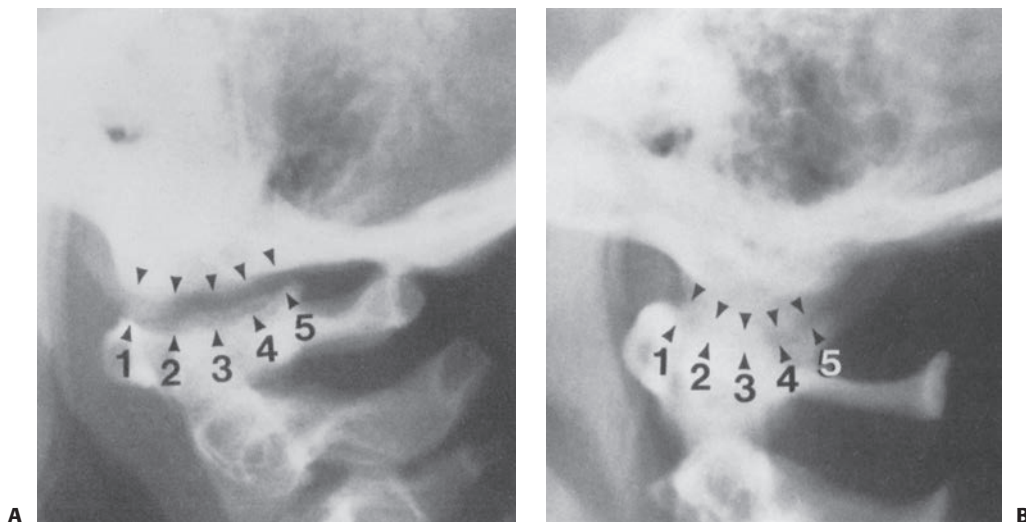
Atlantooccipital joint measurement points 1 through 5 demonstrated on a normal cross-table lateral skull radiograph in an 8-year-old (A) and a 14-year-old (B). (From Kaufman RA, Carroll CD, Buncher CR. Atlantooccipital junction: standards for measurement in normal children. *AJNR Am J Neuroradiol.* 1987; 8:995–999, with permission.)
